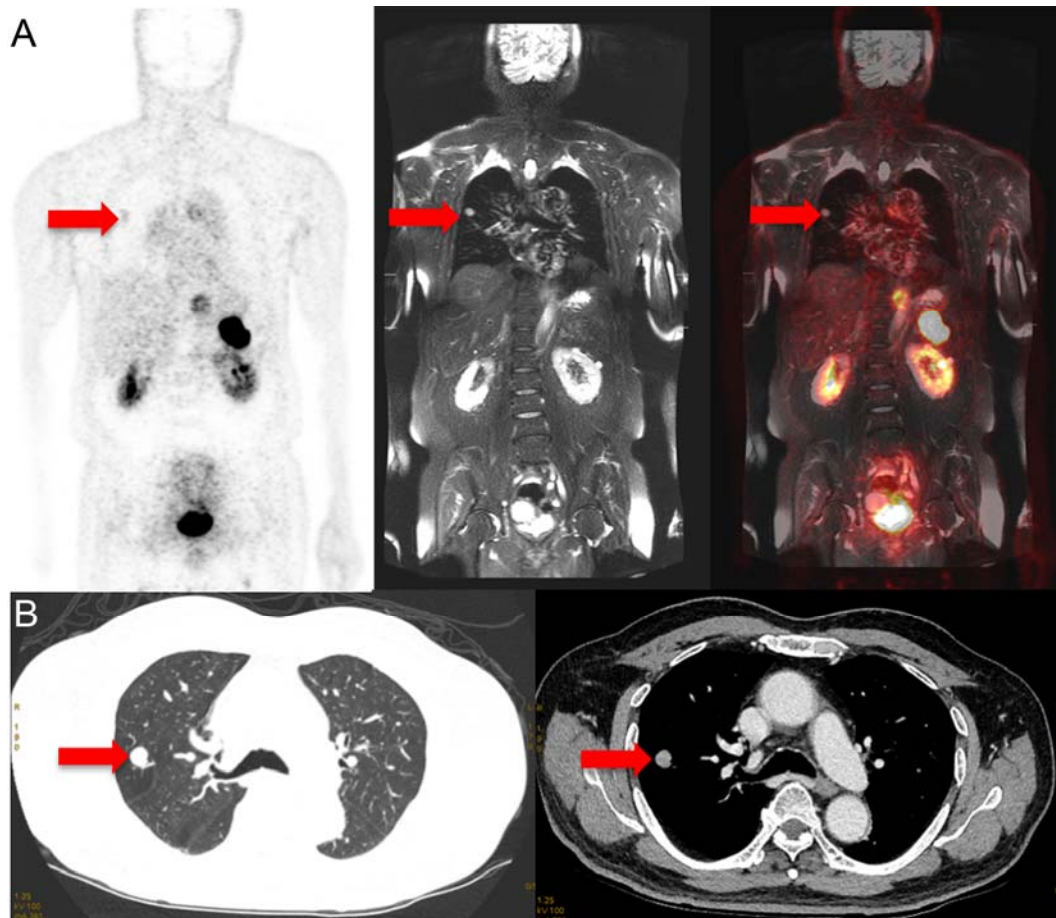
66 year-old man (participant #20) with PCa treated with surgery, radiation therapy and androgen deprivation therapy at initial presentation (Gleason 5+4), now with BCR since 2010 and rising PSA (0.07 to 10.1 ng/ml at time of the scan). (A) Coronal ^{68}Ga -RM2 PET images show faint (but above adjacent normal lung parenchyma) focal uptake corresponding to a lung nodule on MRI (T2w) and fused PET/MRI. (B) Follow-up dedicated chest CT done 2 weeks later demonstrates the lung nodule that was biopsy-proven to represent metastatic adenocarcinoma of prostate origin.
